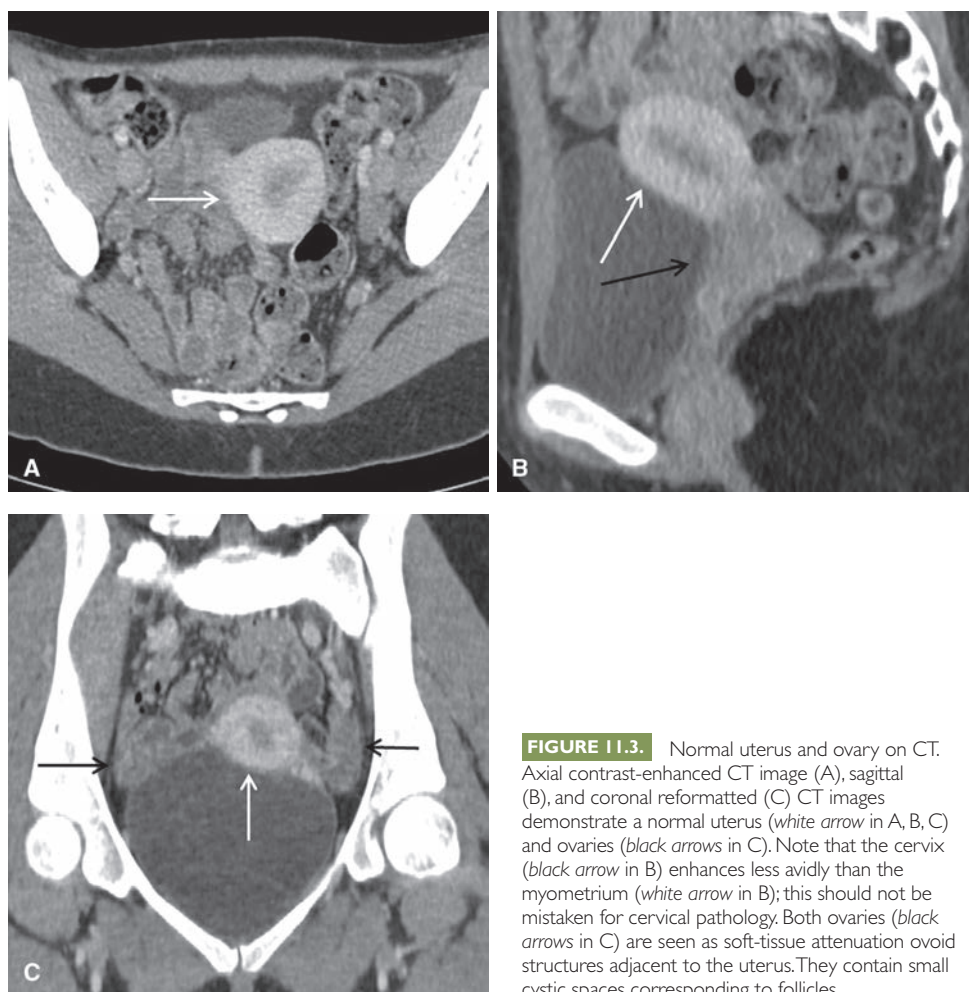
Normal uterus and ovary on CT. Axial contrast-enhanced CT image (A), sagittal (B), and coronal reformatted (C) CT images demonstrate a normal uterus (white arrow in A, B, C) and ovaries (black arrows in C). Note that the cervix (black arrow in B) enhances less avidly than the myometrium (white arrow in B); this should not be mistaken for cervical pathology. Both ovaries (black arrows in C) are seen as soft-tissue attenuation ovoid structures adjacent to the uterus. They contain small cystic spaces corresponding to follicles.
